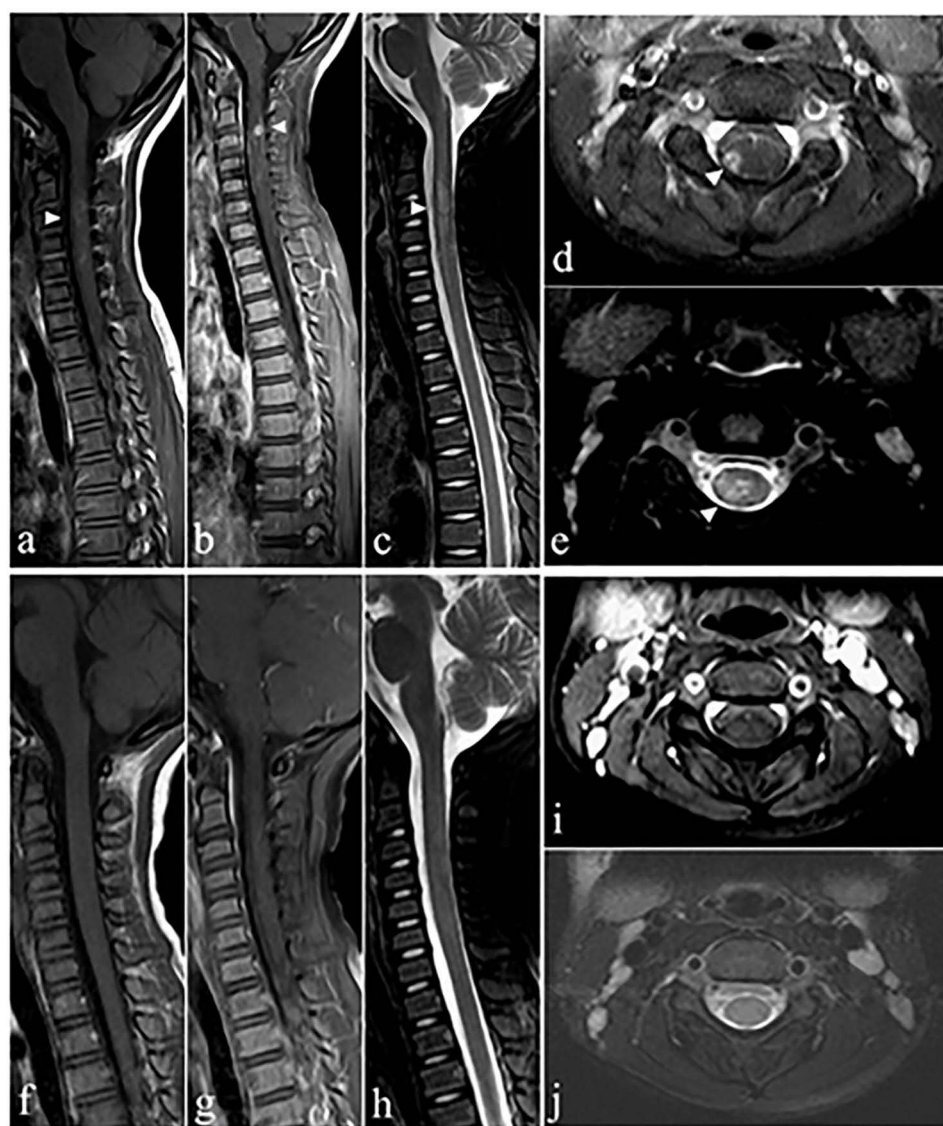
MRI imaging of a 5-year-old patient shows a lesion in the cervical spinal cord (patient 4). As indicated by the white arrowheads, sagittal T1WI (a), contrast-enhanced T1WI (b and d), sagittal T2WI (c), and axial T2WI (e) show a lesion located in the spinal cord extends from C2 to C5. Multiple irregular hemorrhagic areas are present within the lesion, with hyperintensity on T1WI and T2WI. Contrast-enhanced T1WI shows circumferential enhancement within the lesion (b and d). The cervical spinal cord lesion disappeared after two weeks of praziquantel treatment (f–j).
